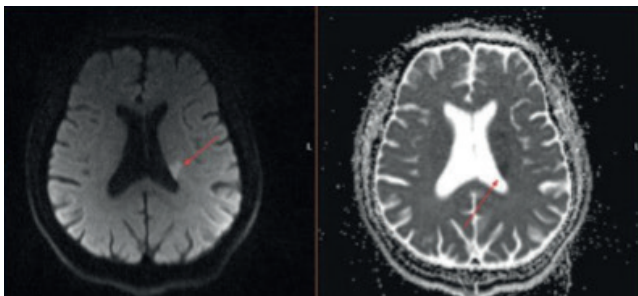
Diffusion magnetic resonance imaging of the patient showed an infarction detected in the area adjacent to the left lateral ventricle (red arrow)
